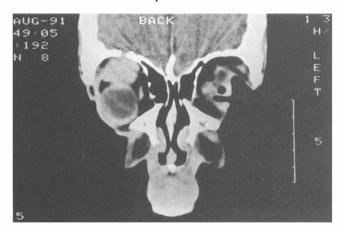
Coronal CT scan showing a right orbital mass depressing the eye and eroding the floor of the anterior cranial fossa.
